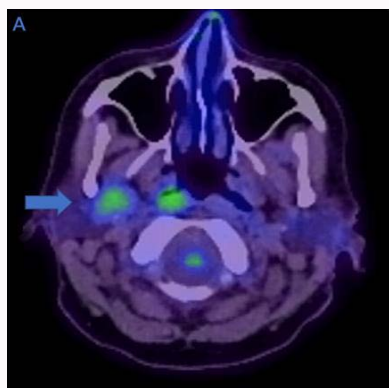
Axial fused 18-FDG PET/CT. (A) Slightly and uniformly metabolic uptake within the right parotid deep lobe (SUVmax 2.3).
